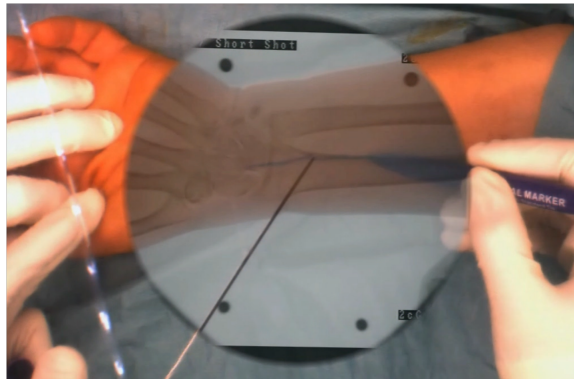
intra-operative combined optical fluoroscopy shot. Surgeon visualizes intra-operative X-ray overlaid on video image in order to place incision correctly. Image courtesy of Lejing Wang, Chair for Computer-Aided Medical Procedures, TUM.
